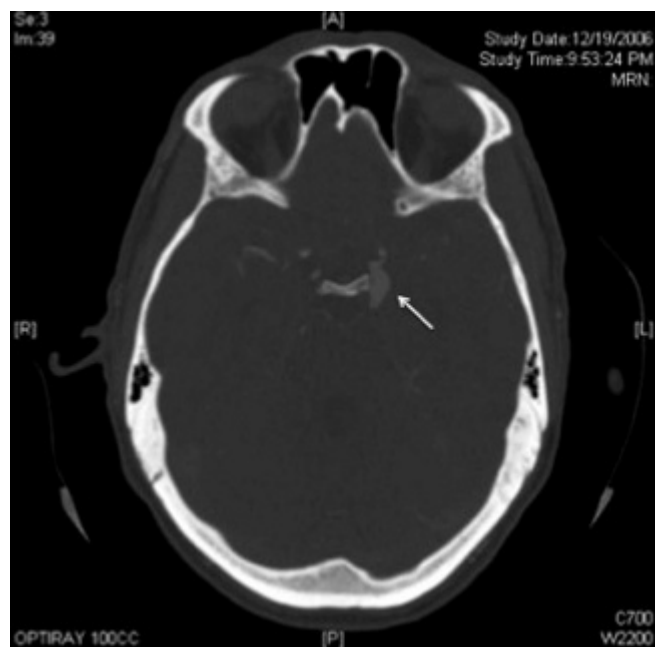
Head computed tomographic angiogram demonstrating a large left posterior communicating artery aneurysm (arrow).
